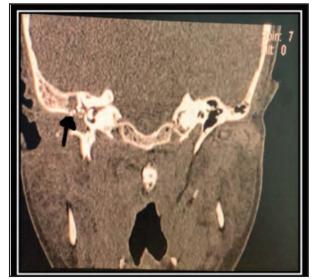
CT scan without contrast Mastoid Coronal view showing scutum erosion (black arrow)
